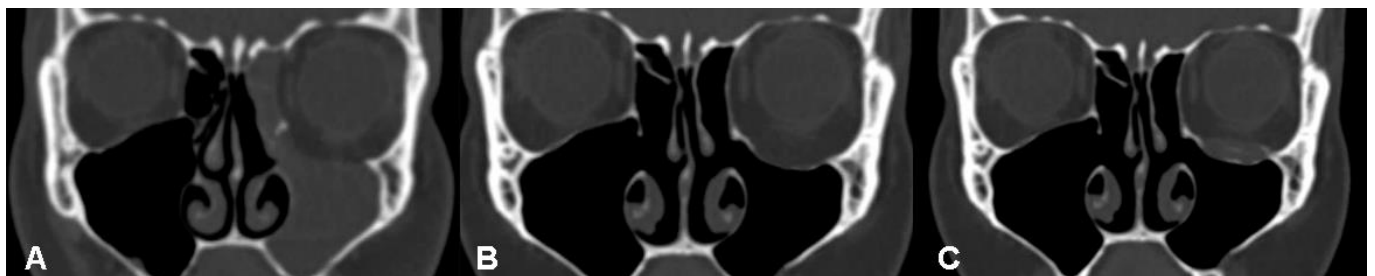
Multislice computed tomography scan of the paranasal sinuses of a patient with silent sinus syndrome at admission (A), 6 months after functional endoscopic sinus surgery (B), and one month after orbital floor surgery (C).
